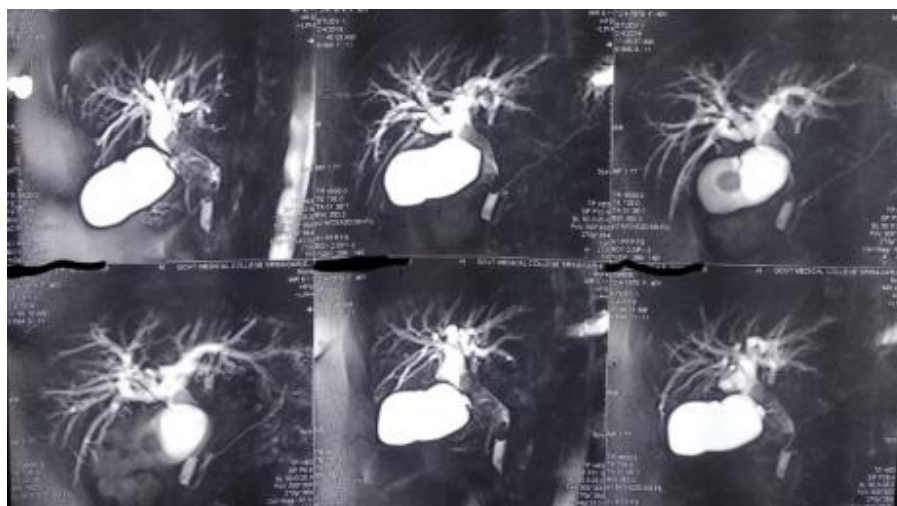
MRI PICTURE SHOWING MULTIPLE FILLING DEFECTS WITH INTRAHEPATIC DUCT DILATION AND STRICTURING
